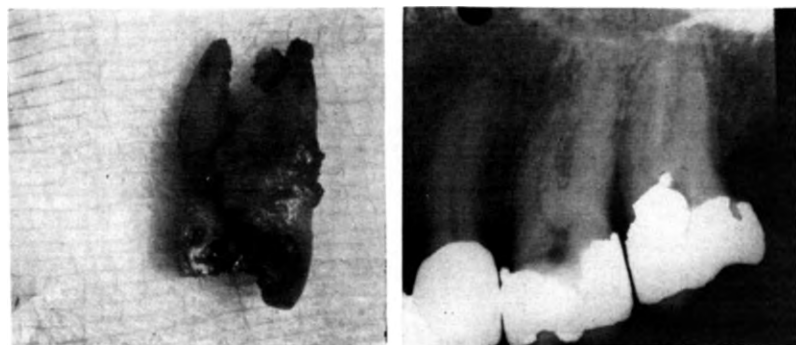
Left, photograph of an inter-radicular lesion in first molar seen from mesiodistal direction, can't be visualized in radiograph at right. Dentin with its high mineral density is masking lesion. It is doubtful whether lesion, because of its position, could be seen radiographically by changing angulations.
